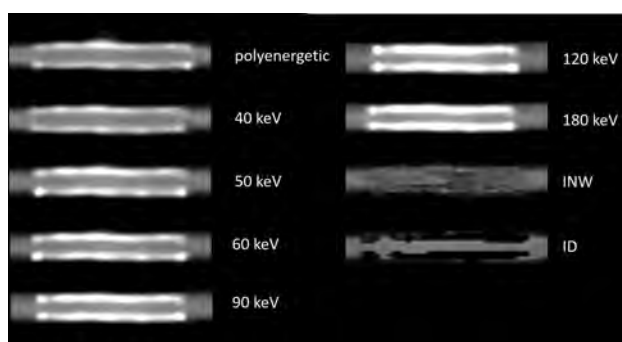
Composition of different reconstructions of the DED. The windowing was adjusted according to the lowest artifact interference and the most comparable vessel appearance (adjusted settings depending on the type of reconstruction; see Materials and Methods, CT Acquisition Parameters).
